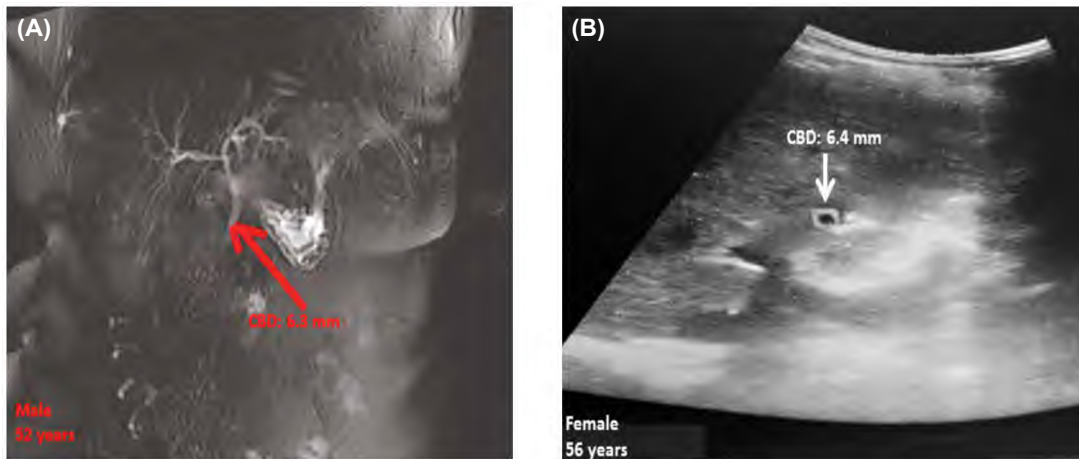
Radiological images of 2 patients of the age group of 50-60 years old with previously surgically removed GB with 6.3 ± 0.5 mm diameter of the CBD. (A) MRCP image of a 52 years old male (B) Trans abdominal ultrasound image of a 56 years old female.
